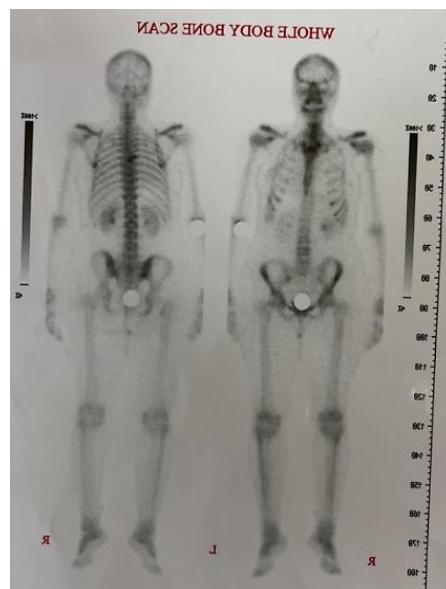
Whole body scan showing a localized area of increased density in the upper thoracic region. Computed tomography (CT)-guided biopsy was consistent with leiomyosarcoma (LMS).
